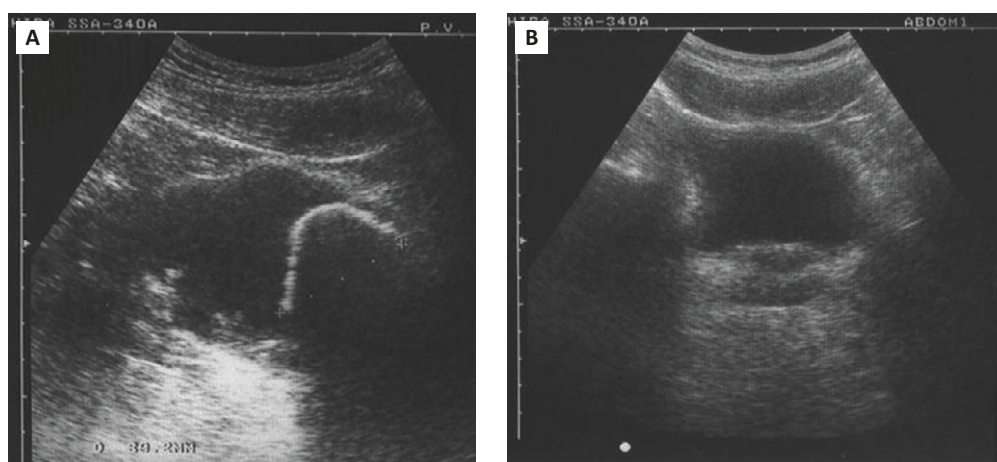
(A) Bladder ultrasound shows a calculus in the urinary bladder. (B) No bladder stones were observed 2 months later in an ultrasound follow-up.
